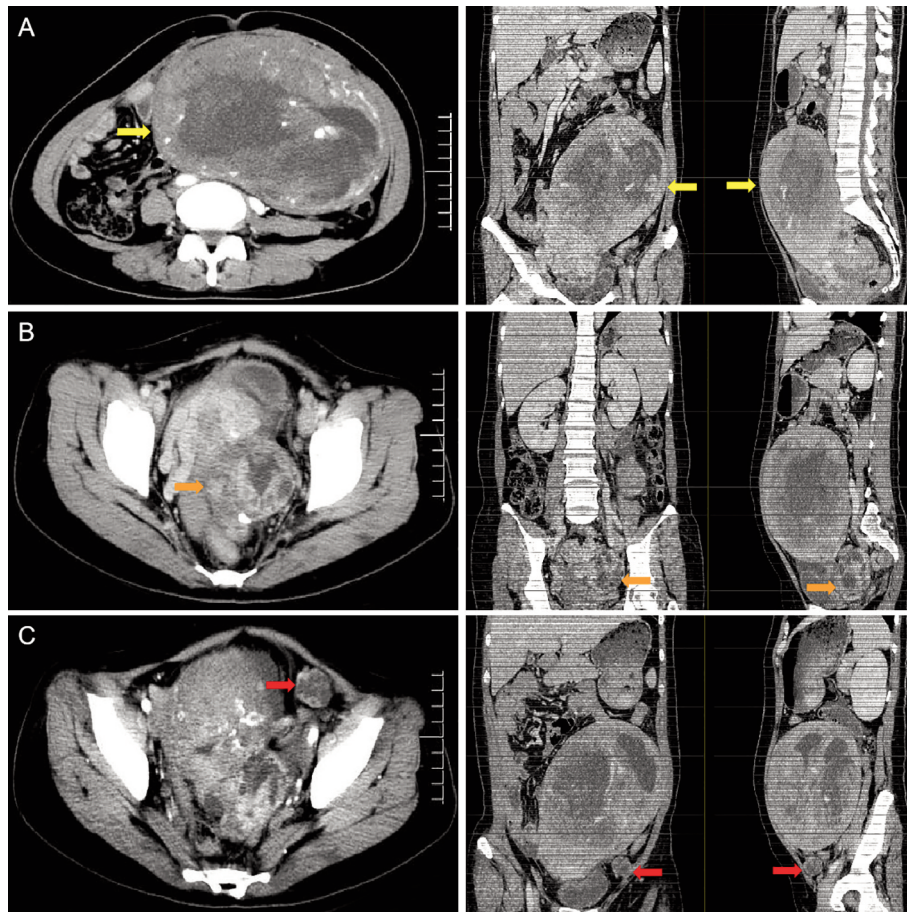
Computed tomography (CT) findings in the axial (left) and coronal and sagittal planes (right). A: CT showed the solid mass in the enlarged uterus (yellow arrows). B: The enlarged cystic solid mass in the ovary was shown by CT (orange arrows). C: CT showing the mass in left pelvic cavity (red arrows).
